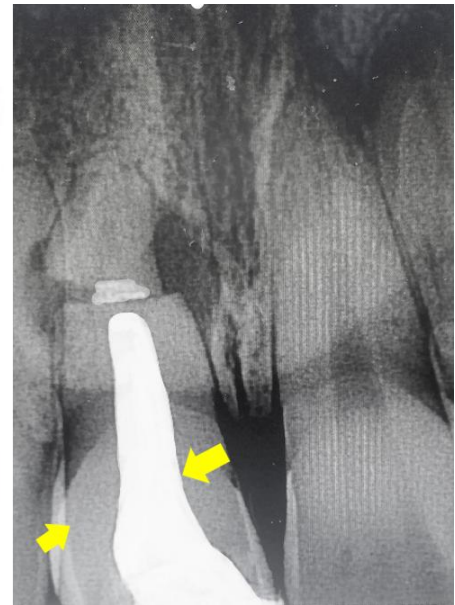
Follow-up radiograph - At 14 months.
